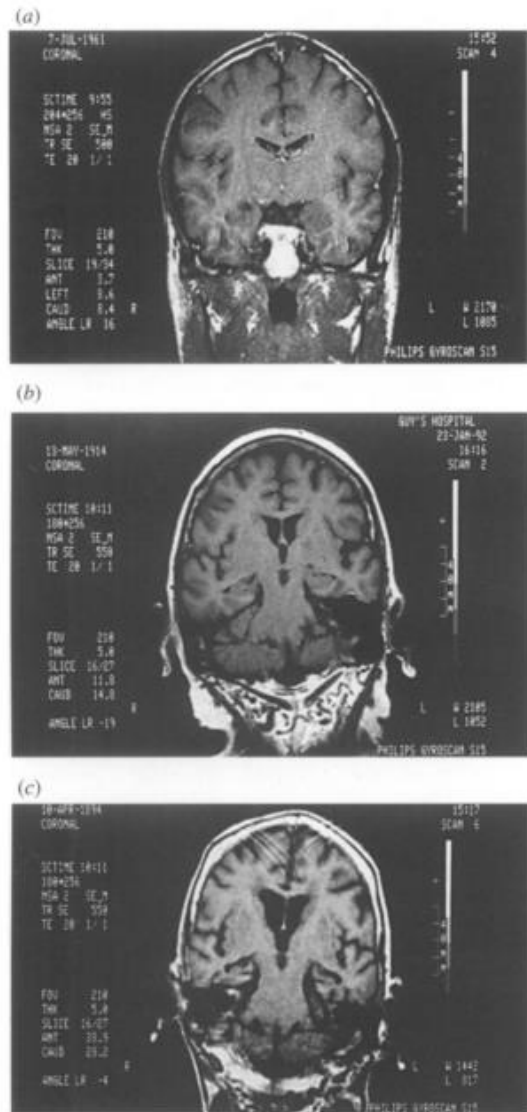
Coronal MRI scans of brains a) of a healthy 35-year-old male, b) a healthy 82-year-old female, and c) a 99-year-old female with AD. From “Changes in the Ageing Brain in Health and Disease,” by B. Anderton, 1997.
